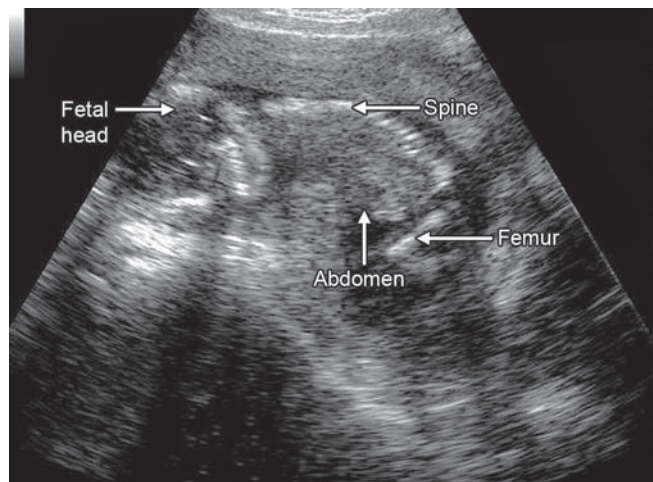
Ultrasound image of a fetus of 16 weeks of gestational age showing fetal head, abdomen and femur
